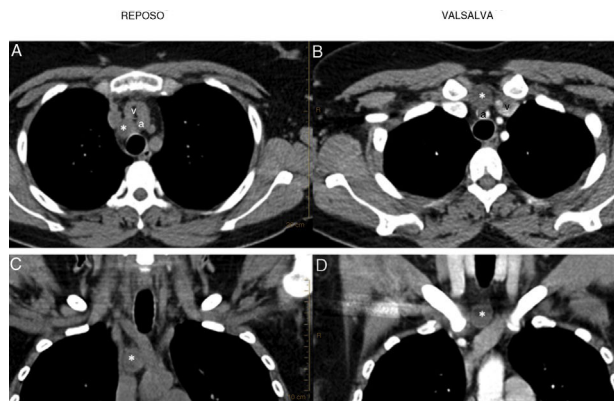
(A and B) CT scan with and without contrast, axial slices at rest and during Valsalva maneuver. (A) At rest, right paratracheal cystic lesion (*) located posterior to the trunk of the innominate veins (v) and posterolateral to the arterial brachiocephalic trunk (a). (B) In the Valsalva maneuver, the cystic lesion (*) rises through the fat of the upper mediastinum to the suprasternal cervical region, to a site anterior to the trunk of the innominate veins (v) and the arterial brachiocephalic trunk (a). (C and D) CT coronal reconstruction at rest (C) and during Valsalva maneuver (D). It can be seen that during the Valsalva maneuver, the cyst (*) rises approximately 3 cm from the mediastinum to the site in the cervical region.
